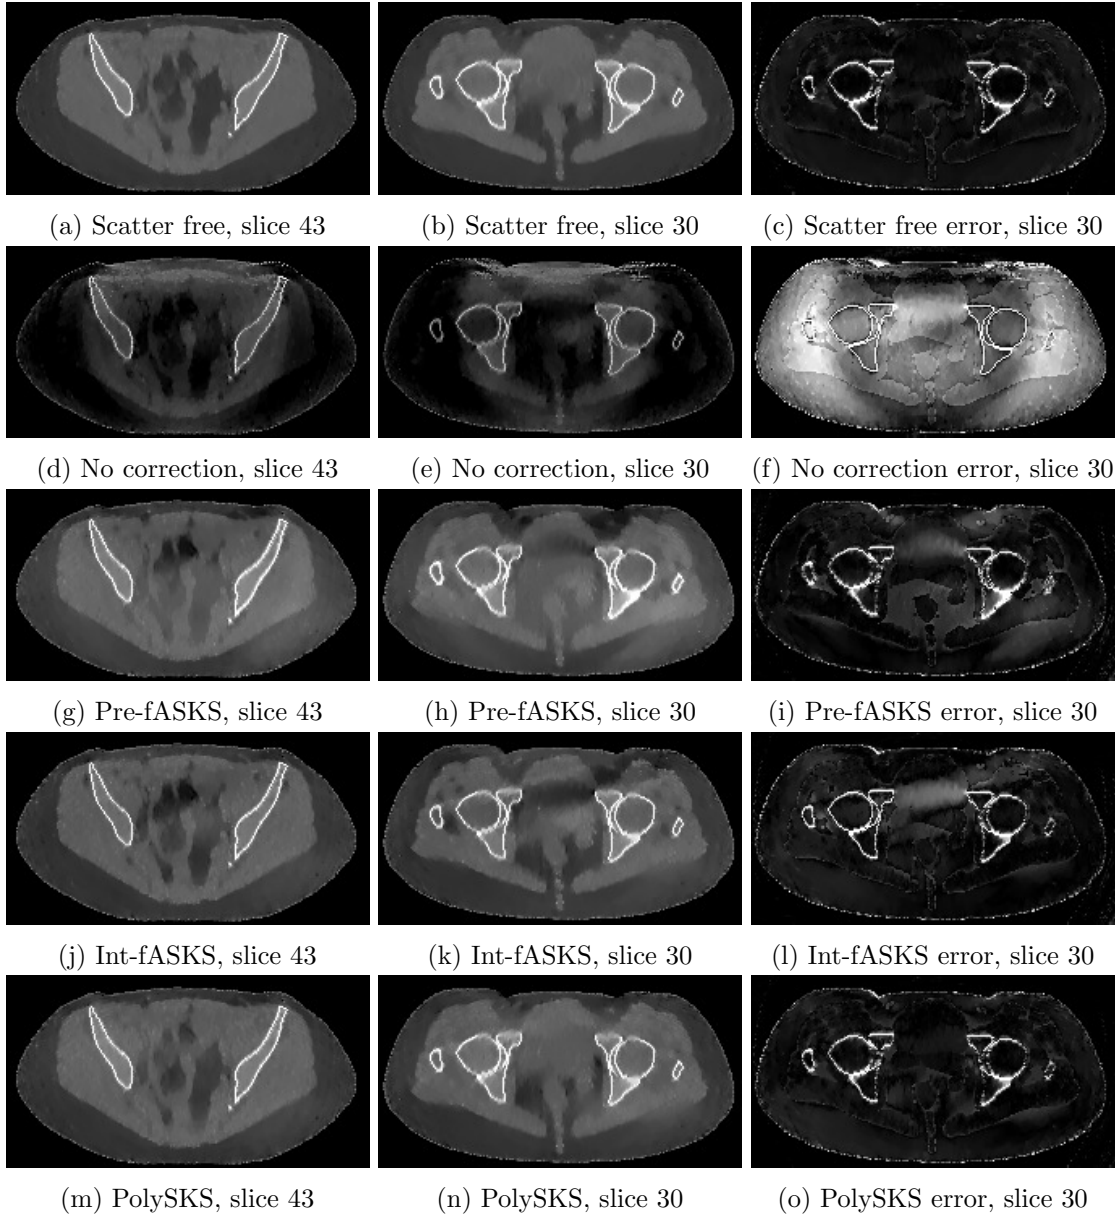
Visual results of slices 43 and 30 from the pelvis CBCT data with display window  $[0.8, 1.4]$  to aid visualisation of soft tissue and reconstruction artefacts; absolute errors have display window  $[0, 0.3]$ .
